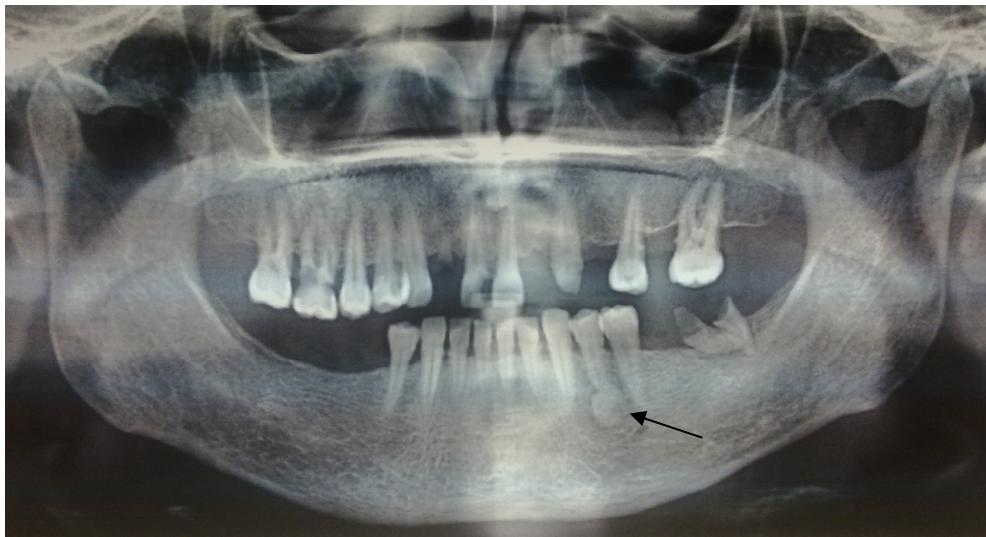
Panoramic radiographic view of cementoblastoma related to mandibular premolar tooth.
